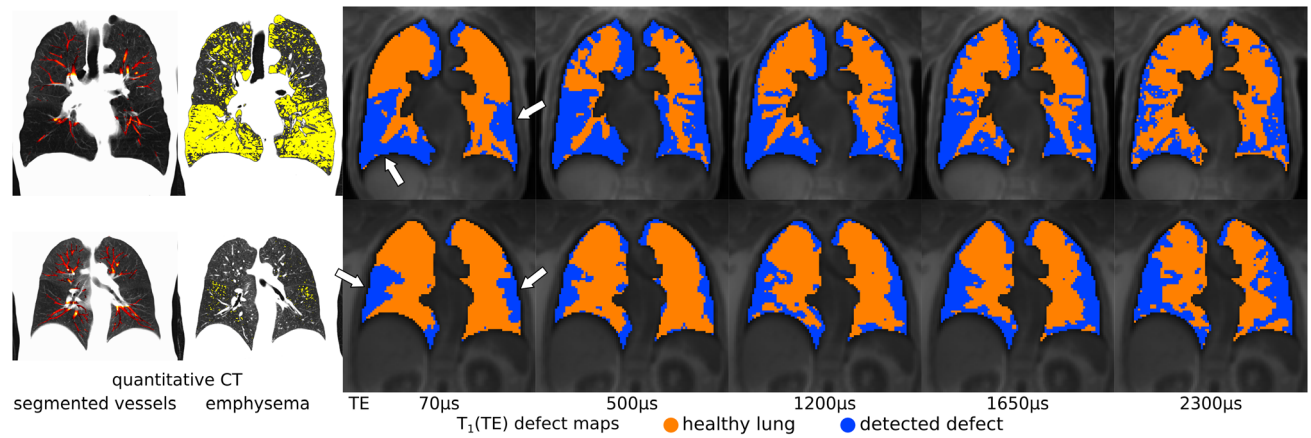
Vessels (marked in red) and local emphysema (yellow) detected by quantitative CT and example maps of defects detected using $T_1(TE)$. The $T_1(TE)$ defect maps directly correspond to Fig. 2, and show the same slices. Defects have been highlighted using arrows.
